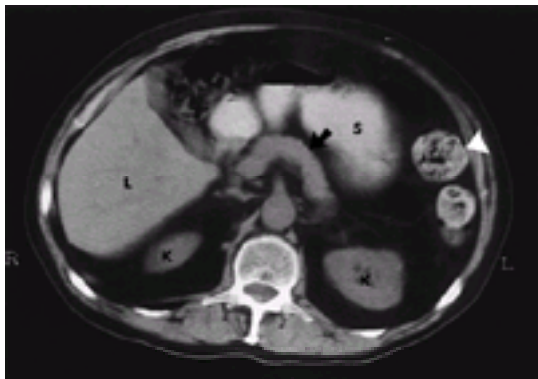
Normal CT section of the upper abdomen, showing the liver (L), the kidneys (K), and the pancreas (arrow). Note that the organs are identified because the intervening fat has a lower attenuation value than other soft tissues. Oral contrast medium has been given and outlines the stomach (S) and descending colon (arrowhead).
